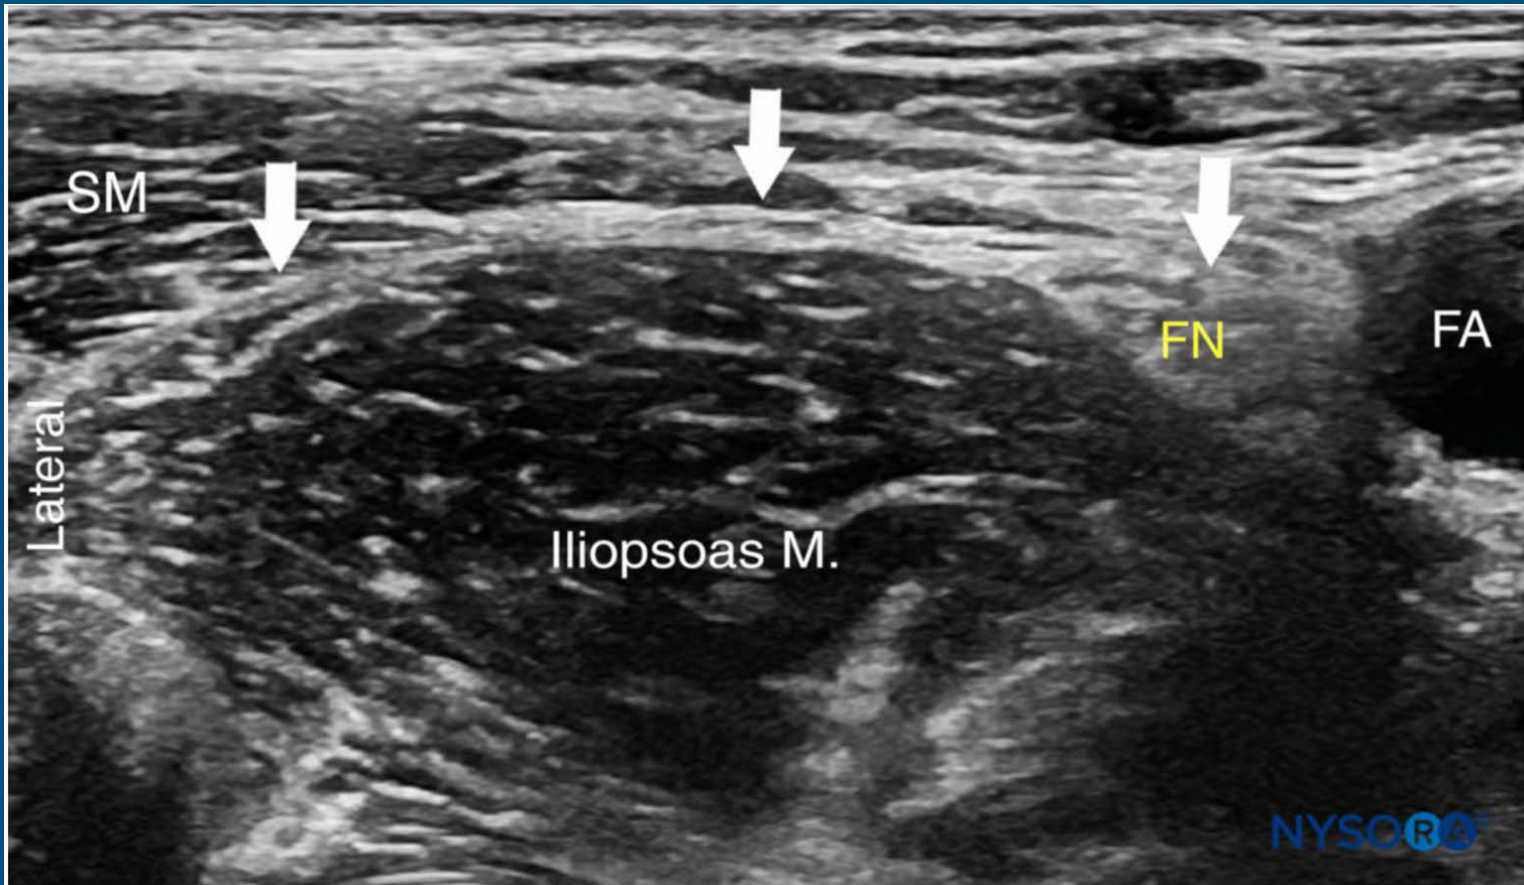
Ultrasound image of the fascia iliaca (white line and arrows) at the level of the inguinal ligament. The femoral nerve (FN) and femoral artery (FA) are visualized on the medial side and the sartorius muscle (SM) on the lateral side.
